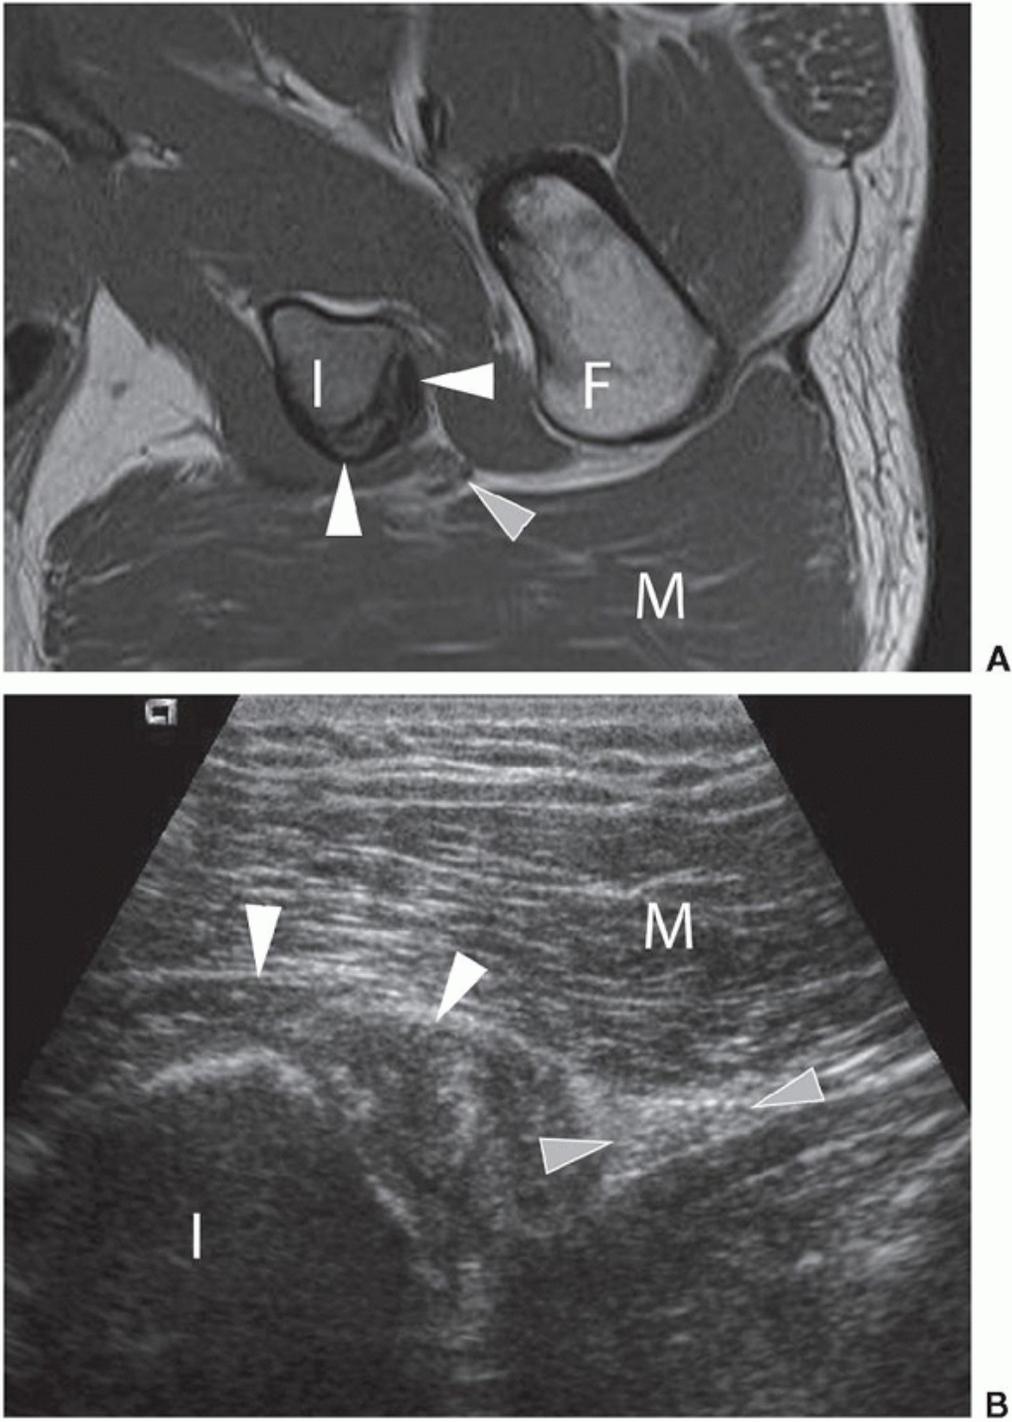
Normal axial/TS views of the ischial tuberosity. A: Axial TW1 MRI and B: Transverse sonogram shows ischial tuberosity (I), femur (F), gluteus maximus (M), hamstring origins (white arrowheads) and sciatic nerve (gray arrowheads).
